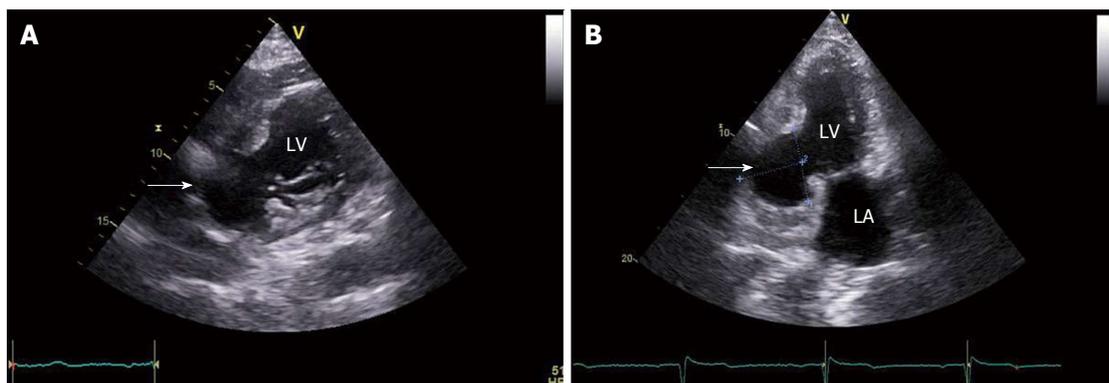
Echocardiography: Parasternal short axis and 2-Chamber view of the left ventricle posterior wall pseudoaneurysm (A and B, arrows). LA: Left atrium; LV: Left ventricle.
